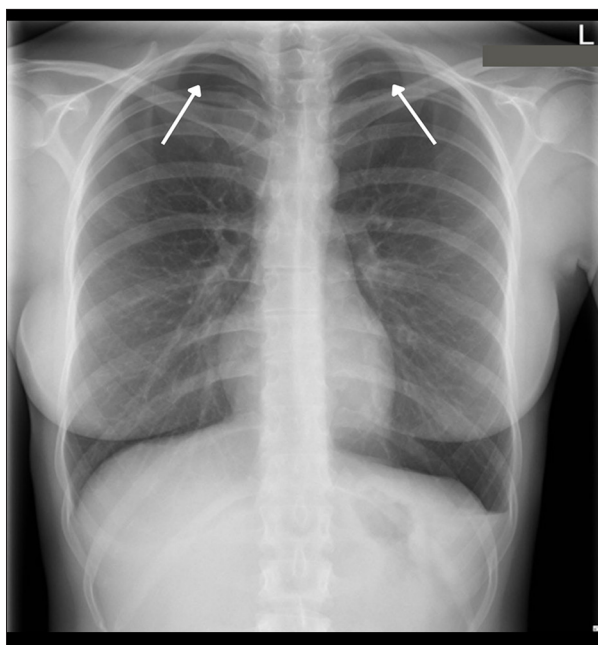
Posteroanterior chest radiograph obtained in the emergency department showing bilateral apical pneumothoraces (arrows), greater on the right side.
